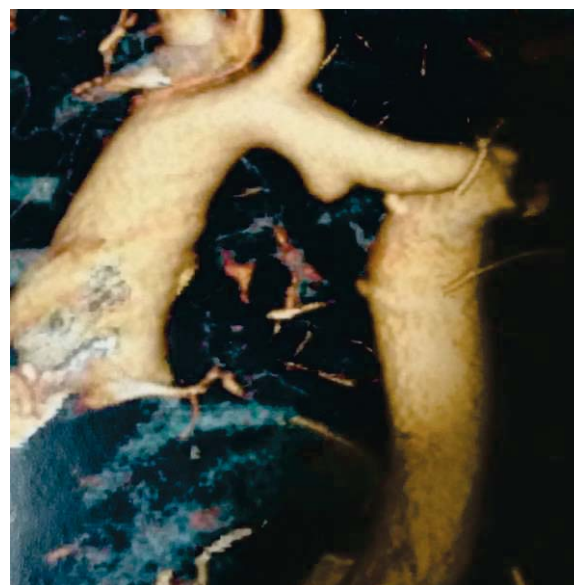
CT angiography of aorta: Ascendant aorta 30mm, aortic arch 20mm, both hypoplastic Ao descendens narrower (15-16 mm) distal to the origin of the left CCA, restenosis on the narrowest part of the thoracic aorta-10x12 mm, dilatation distally to the narrowing -22 mm. Left arteria subclavia missing.
